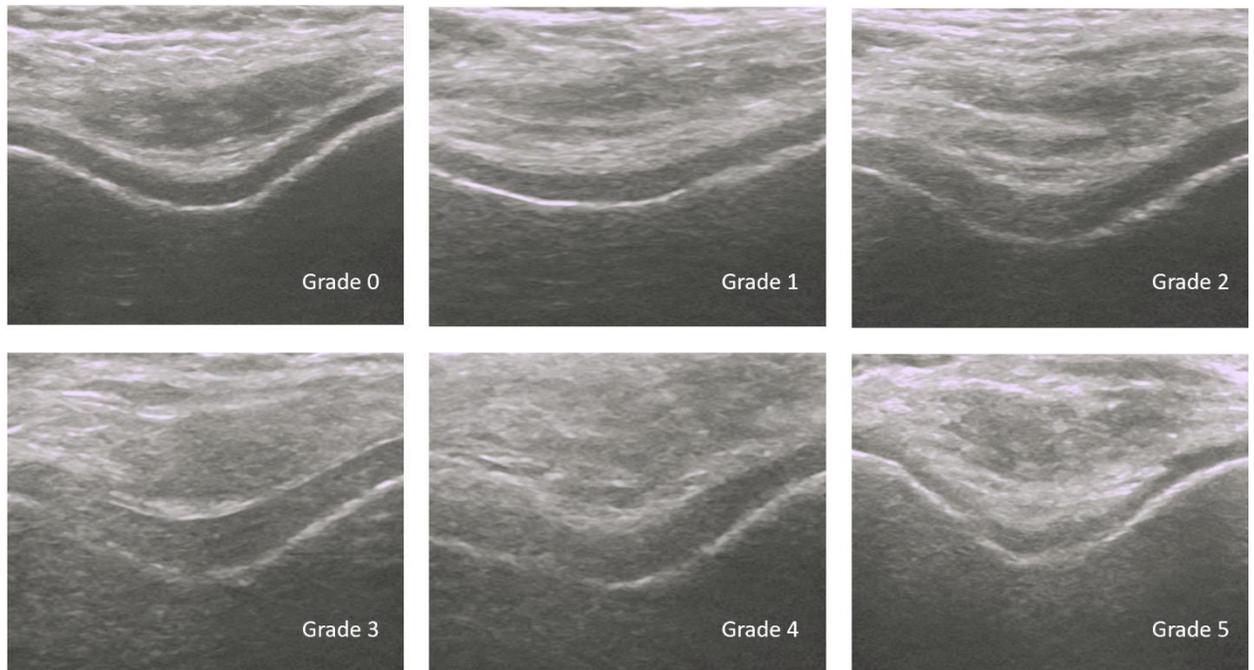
Ultrasound grading of femoral cartilage. Grade 0: Sharp cartilage edges. Grade 1: blurred margin or partial lack of the clarity, without thickness change. Grade 2: blurred margin and partial lack of the clarity, without thickness change. Grade 3: blurred margin and complete lack of the clarity. Grade 4: difficult-defined margin and the complete-opaque band. Grade 5: marked thickness change.
